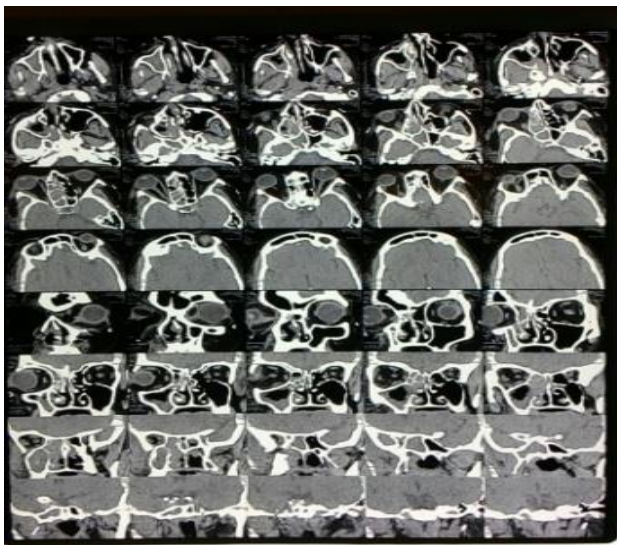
CT Scan showing sign of sinusitis.
